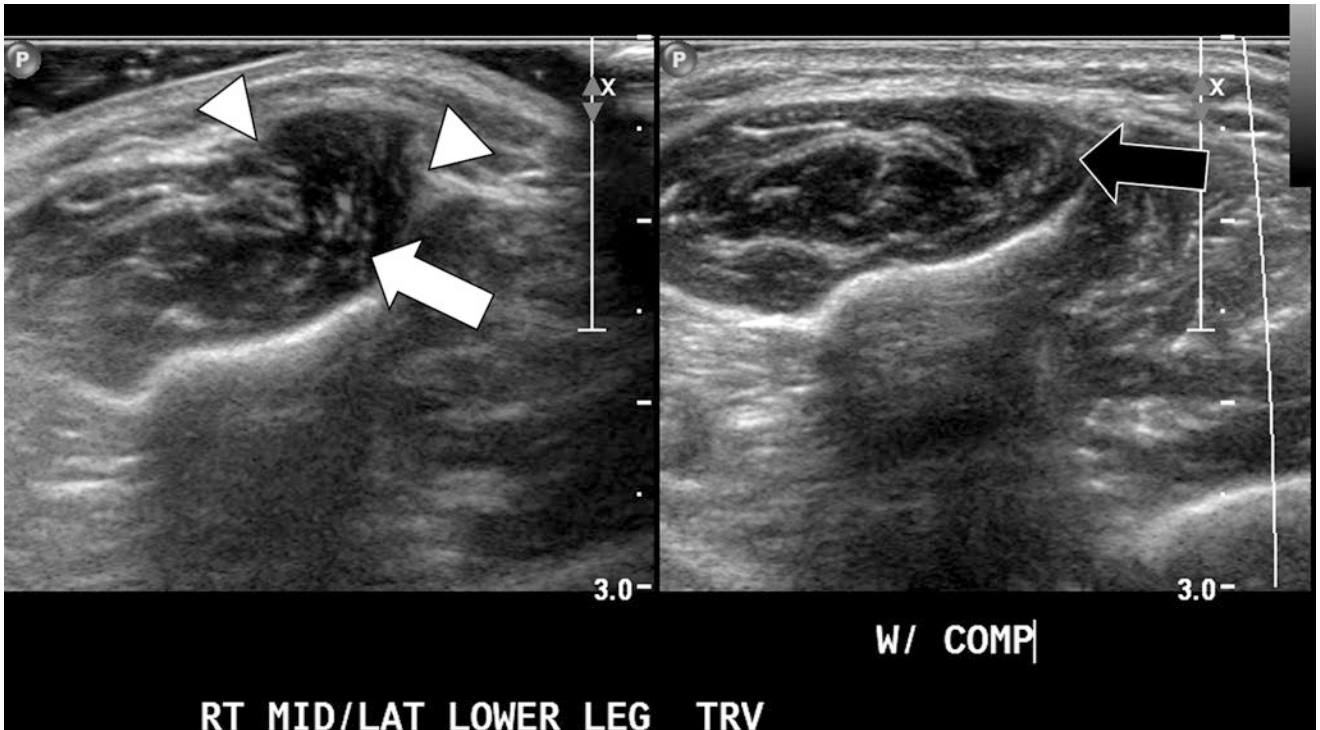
Transverse gray-scale sonographic image of the right lower leg anterior compartment demonstrates a short segment defect in the superficial fascia (white arrowheads) with associated hypoechoic
